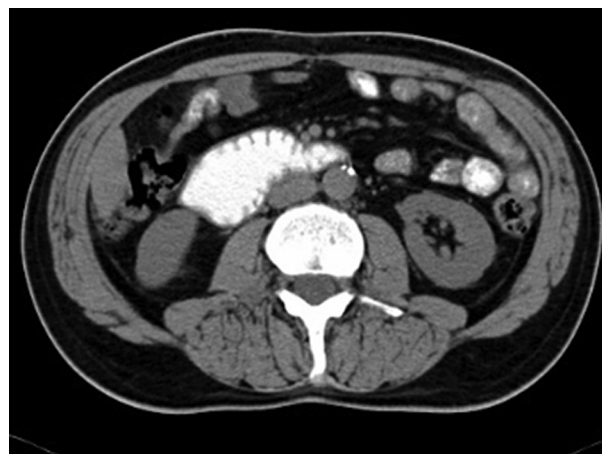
Multislice computed tomography demonstrates a filling defect in the fourth part of the duodenum.
